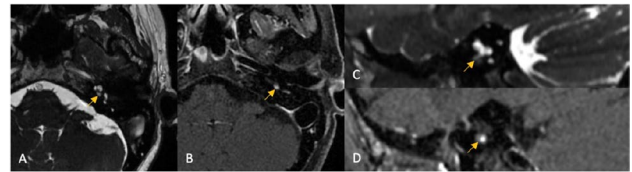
A, Axial high-resolution T2-weighted MR image. B, Axial enhanced T1-weighted MR image. C, Oblique sagittal high-resolution T2-weighted MR image. D, Oblique sagittal enhanced T1-weighted MR image.
